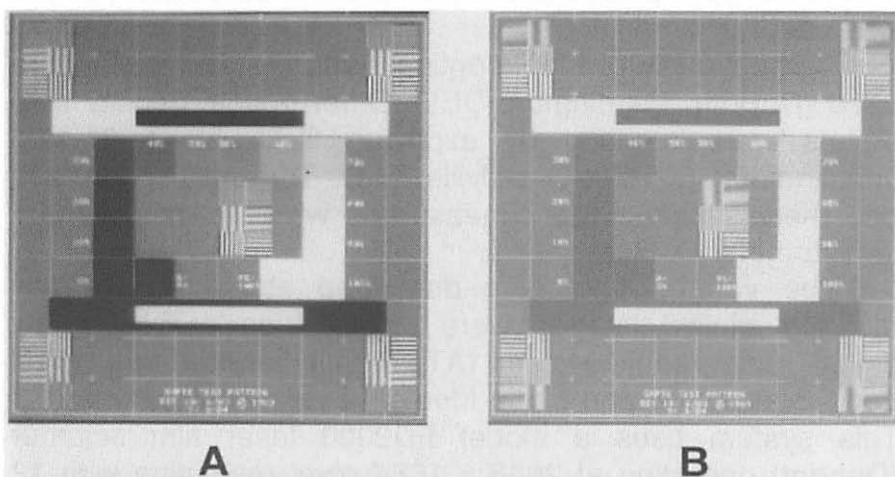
Two SMPTE patterns digitized from a single sheet of x-ray film. A corresponds to a pattern present on the upper half of the film. Streak artifacts are demonstrated at abrupt borders between bright and dark bars in the pattern. B was in the lower portion of the same film. Low contrast definition is degraded as compared to the image in A.
